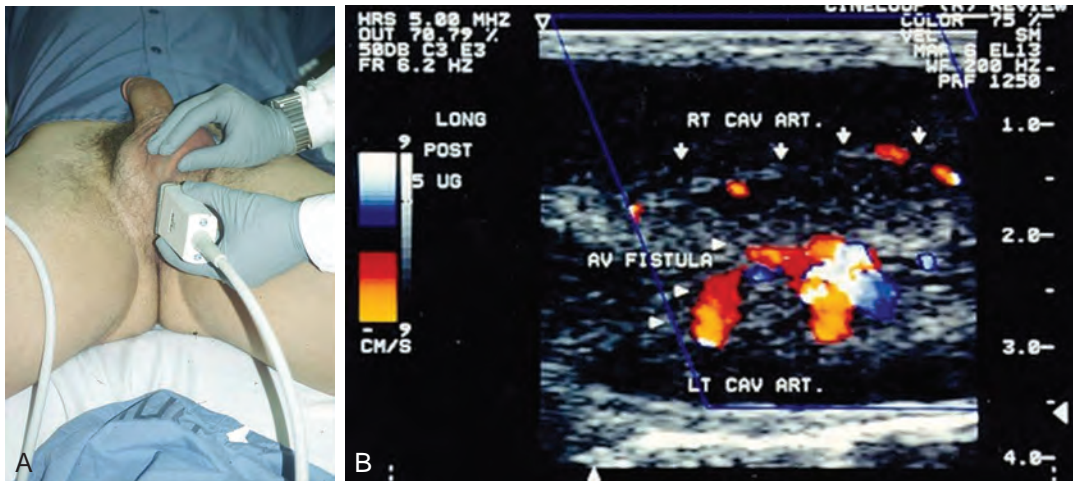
A, Examination of the crural bodies is required when searching for arterial sinusoidal fistula after straddle injury. B, Color Doppler image of arterial sinusoidal fistula of left cavernous artery.
